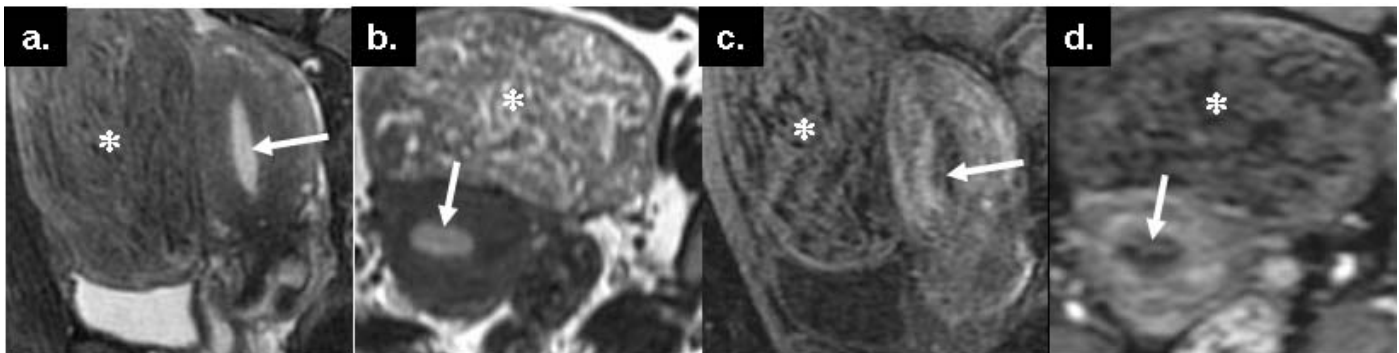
Subserous leiomyoma in a 44-year-old woman. (a.) Sagittal T2-weighted fast SE (8,181/83) MR image shows a pelvic mass (\*) adjacent to the uterus and subtle low signal intensity in the endometrial canal (arrow). (b.) Transverse T2-weighted fast SE (2,000/83) shows the juxtaterine mass (\*) and subtle low signal intensity in the endometrial canal (arrow). (c.) Sagittal SPGR (4.9/2.2) dynamic contrast MR image demonstrate a plate-like enhancement in the endometrial canal. (d.) Transverse SPGR dynamic contrast MR image with multiplanar reconstruction techniques demonstrate the plate-like enhancement in the endometrial canal. This patient underwent hysterectomy 21 days later, and it was proved that the juxtaterine mass was subserous lipoleiomyoma, however, the endometrial canal was normal structure.
